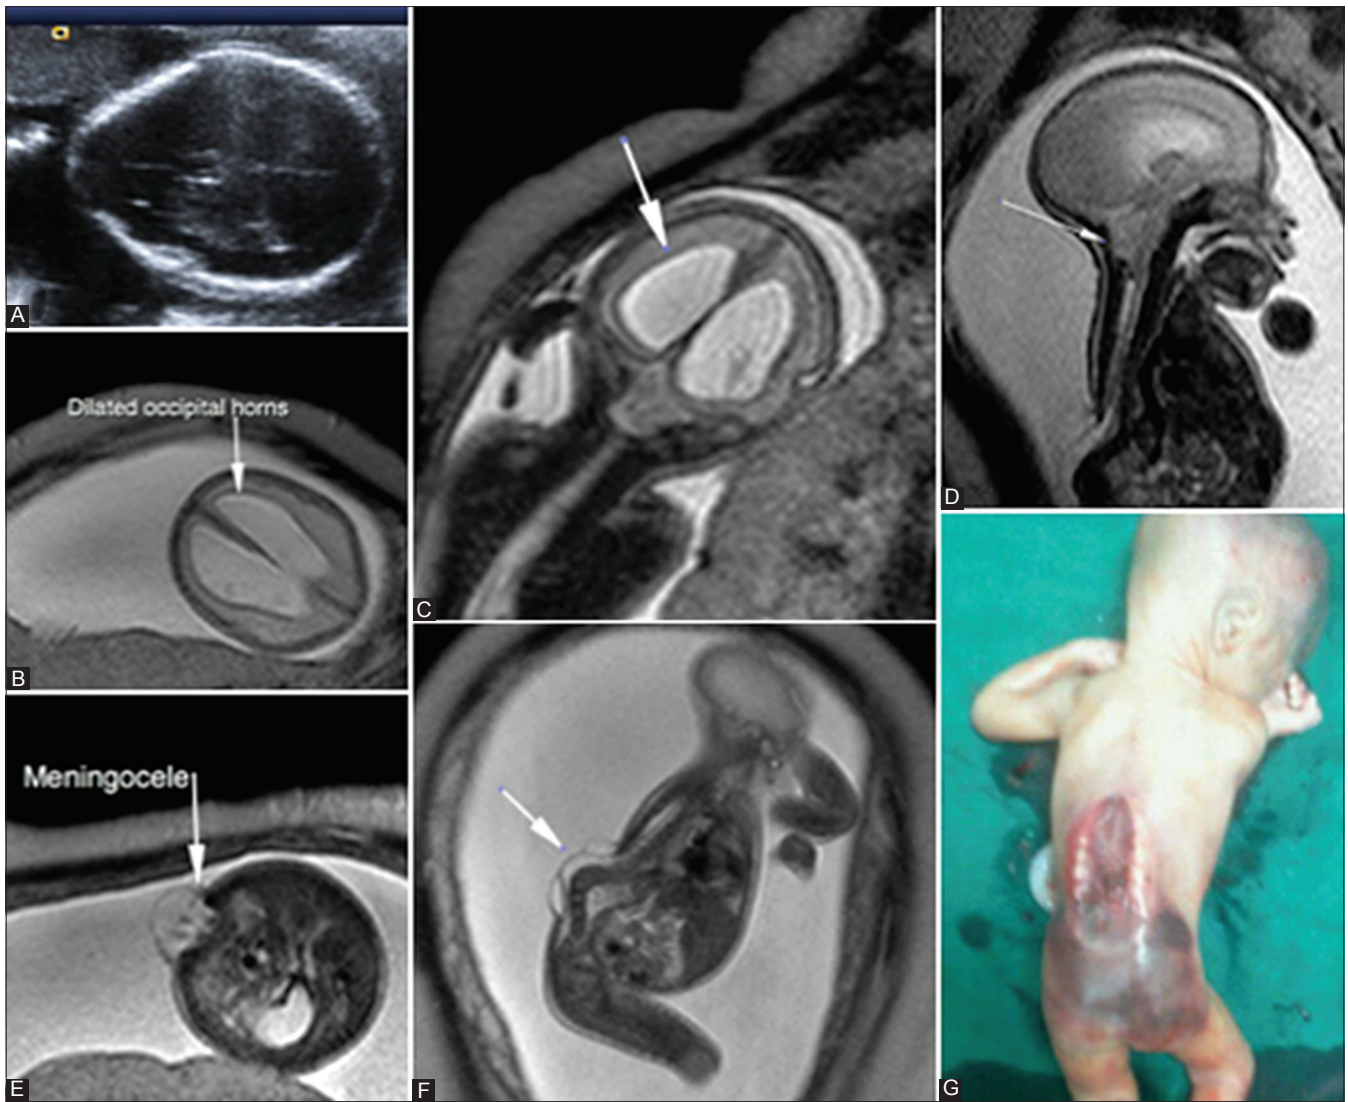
(A-G): (A) Arnold Chiari III malformation at 18 weeks gestation. Axial USG image shows lemon shaped skull, T2WI axial (B) reveal dilated ventricles, coronal T2WI, (C) and sagittal BTFE (D) images show colpocephaly and hydrocephalus. MRI revealed tonsillar herniation which could not be detected on ultrasound. Axial BTFE, (E) sagittal T2WI, (F) and postnatal (G) images show protrusion of CSF and meninges through a dorsal spinal defect into the subcutaneous plane in the lumbosacral region suggestive of meningocele
